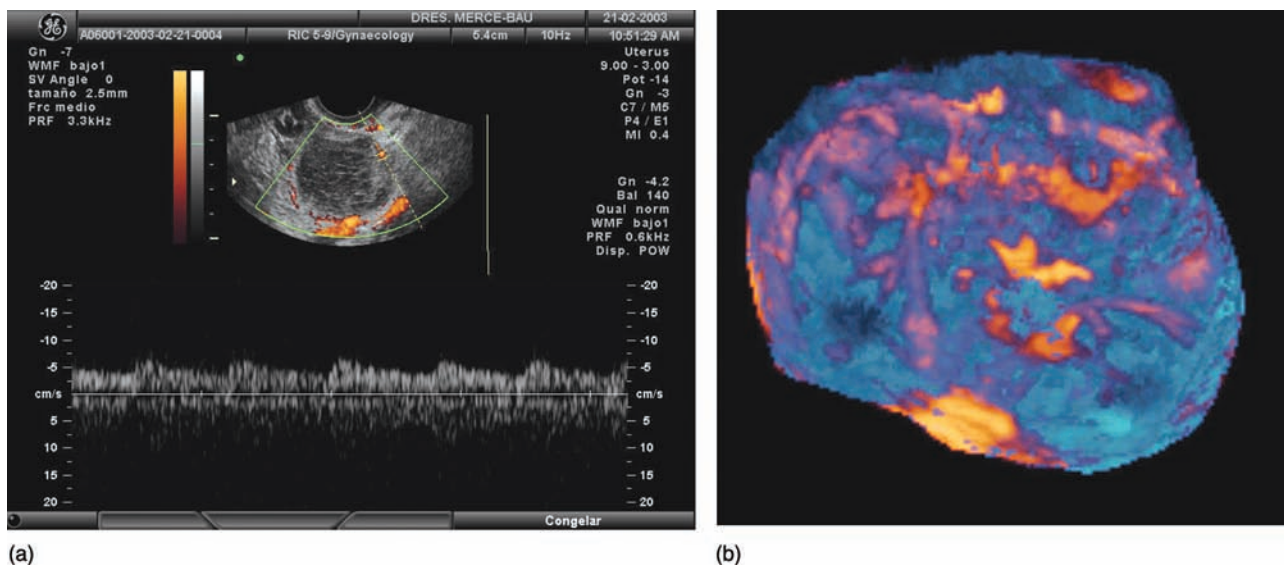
Doppler investigation in the luteinized unruptured follicle (LUF). (a) Three-dimensional angiographic rendering. (b) Arterial and venous FWV. 'Luteal conversion' is not present and venous and arterial velocities are very low.
